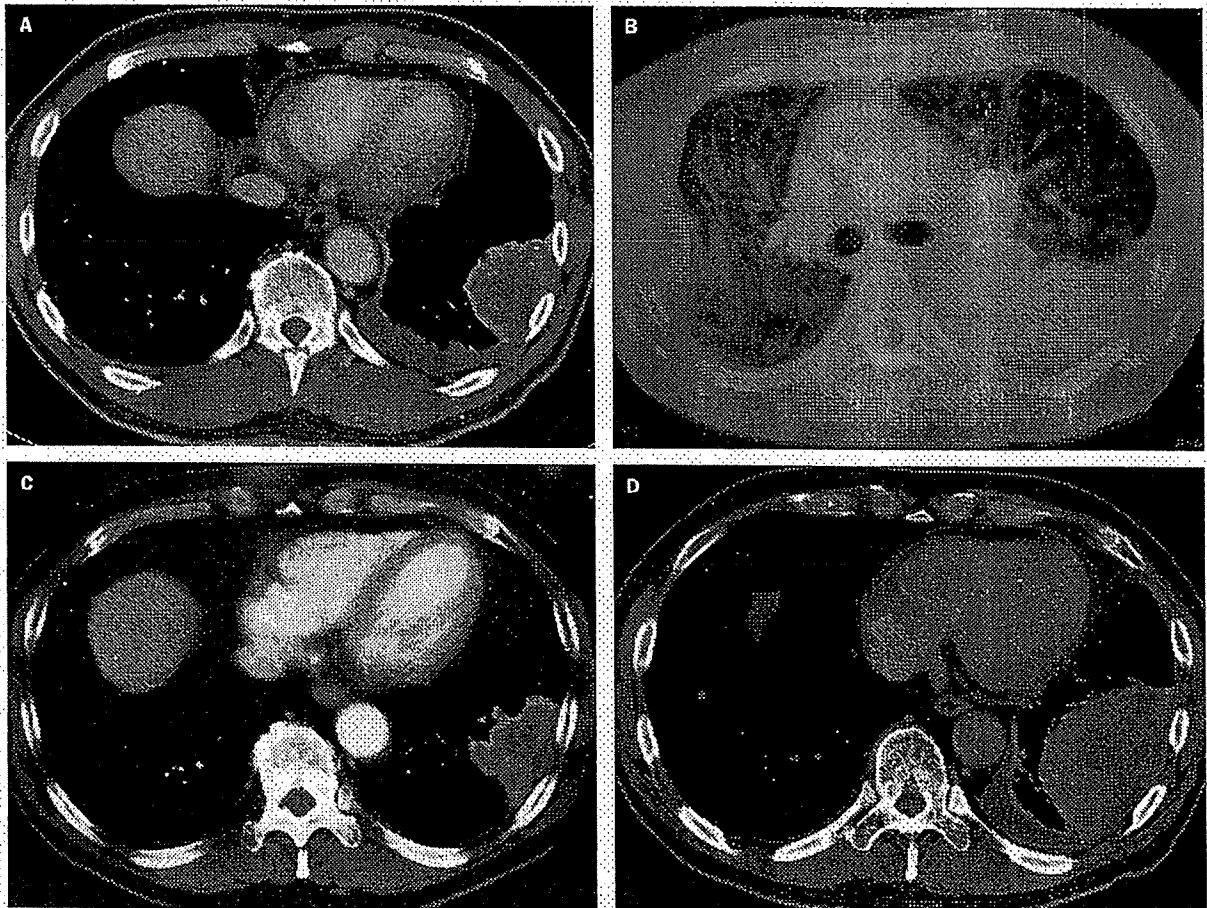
Clinical course of transplantation. A: Lung metastasis and pleural effusion before transplantation. B: Chest CT scan shows ground glass opacity 72 days after transplantation. C: No presence of pleural effusion or lesion 155 days after transplantation. D: Tumour growth 340 days after transplantation.
